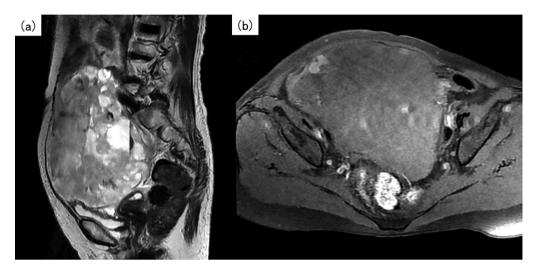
Magnetic resonance image of the tumor. (a) The tumor appears as a solid mass with variable signal intensity on T2-weighted image. (b) Intense enhancement of the tumor is seen on T1-weighted contrast-enhanced image.
